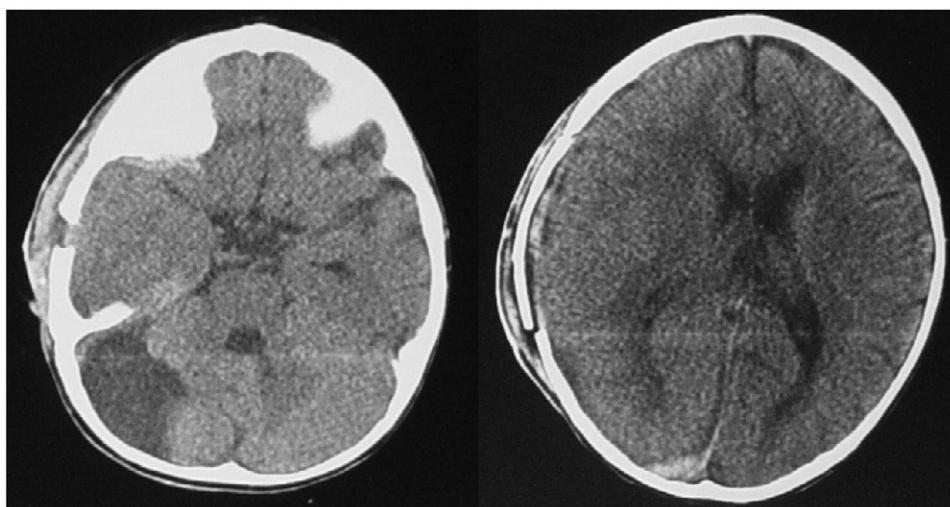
The postoperative CT scans showing no hematoma.
